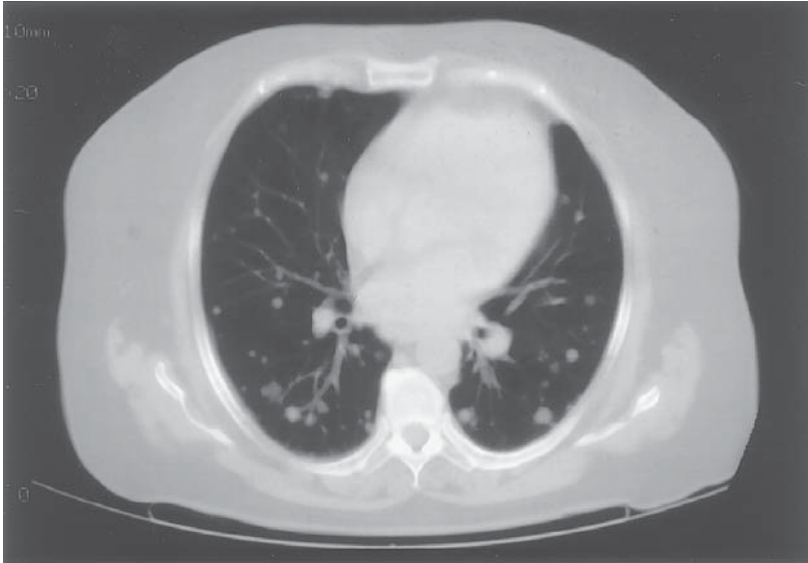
Follow-up chest CT scan in a patient following nephrectomy for RCC. The scan demonstrates innumerable pulmonary metastases. The patient is not a candidate for pulmonary metastasectomy.
